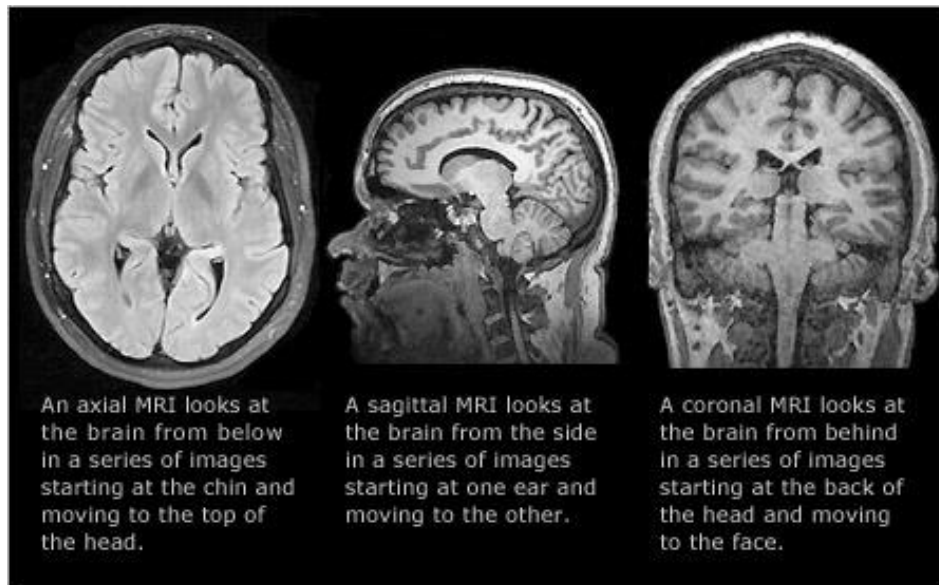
Three type of views for MRI Brain images
